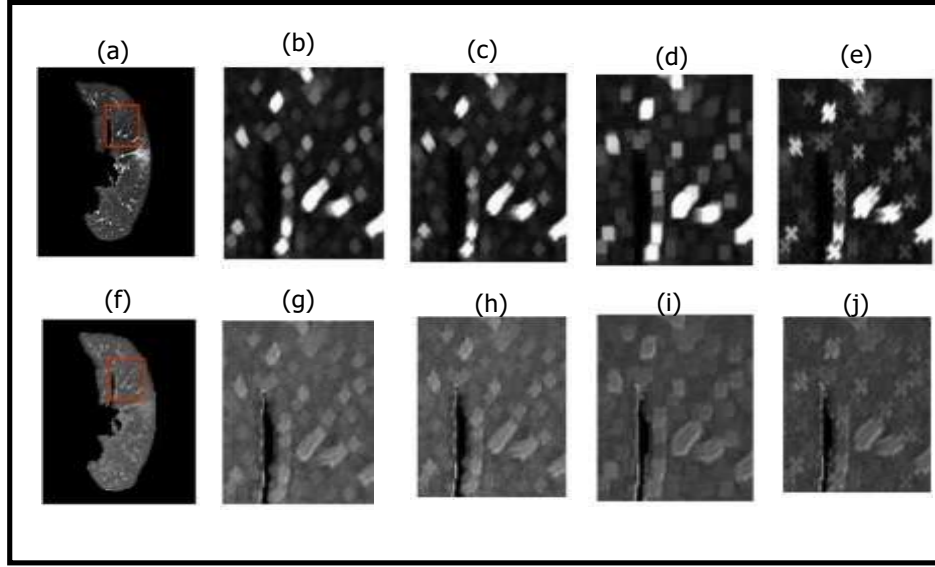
The proposed masking pneumonia regions comparison; (a) a CT-scan image; (b) a dilated structural image by using a „circle“ dilating filter; (c) a dilated structural image by using a „plus“ dilating filter; (d) a dilated structural image by using a „square“ dilating filter; (e) a dilated structural image by using a „circle“ dilating filter; (f) a visualized contrast metric; (g) a visualized contrast metric by using a „circle“ dilating filter; (h) a visualized contrast metric by using a „plus“ dilating filter; (i) a visualized contrast metric by using a „square“ dilating filter; (j) a visualized contrast metric by using a „circle“ dilating filter.
